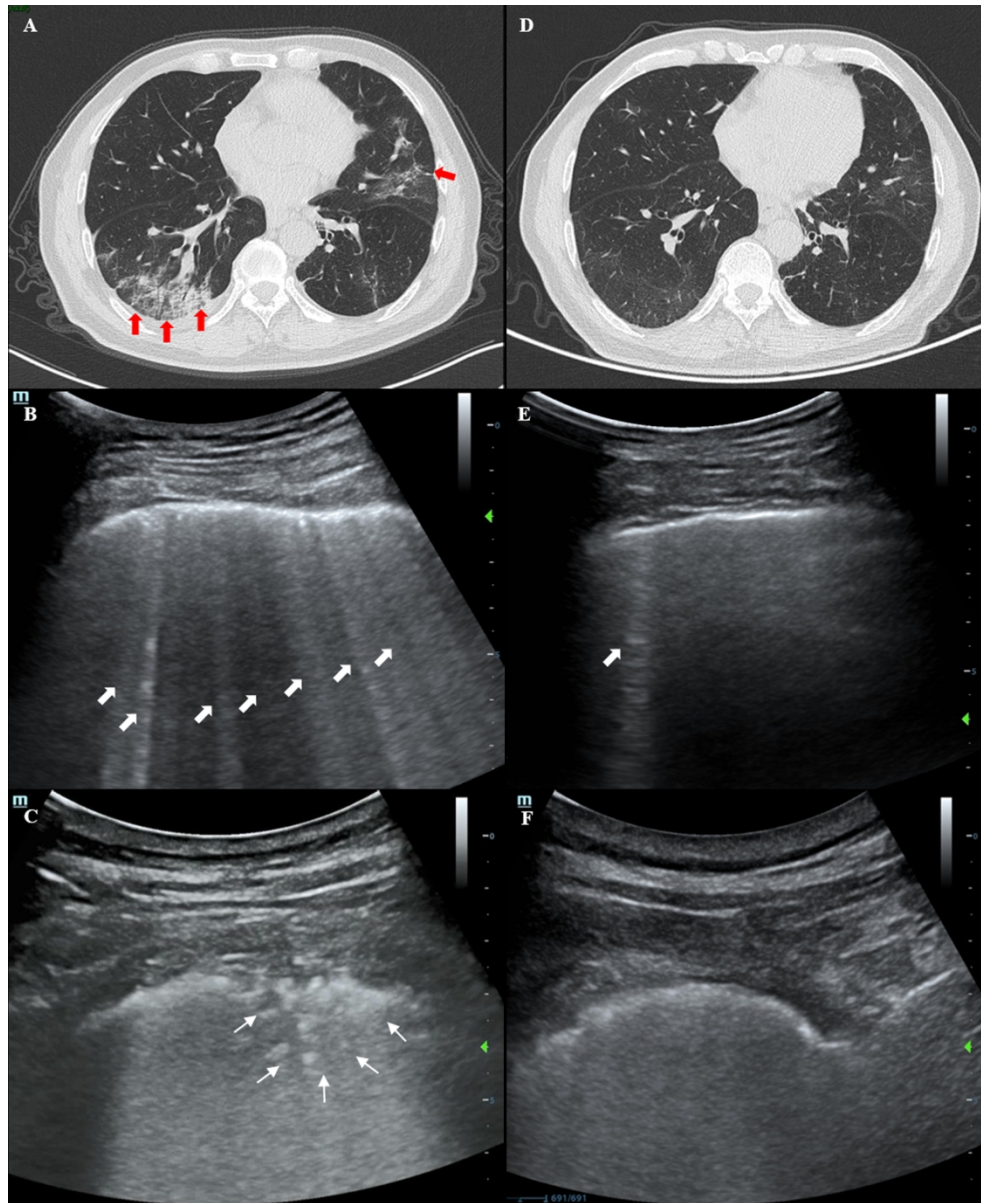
Chest CT and LUS findings.
